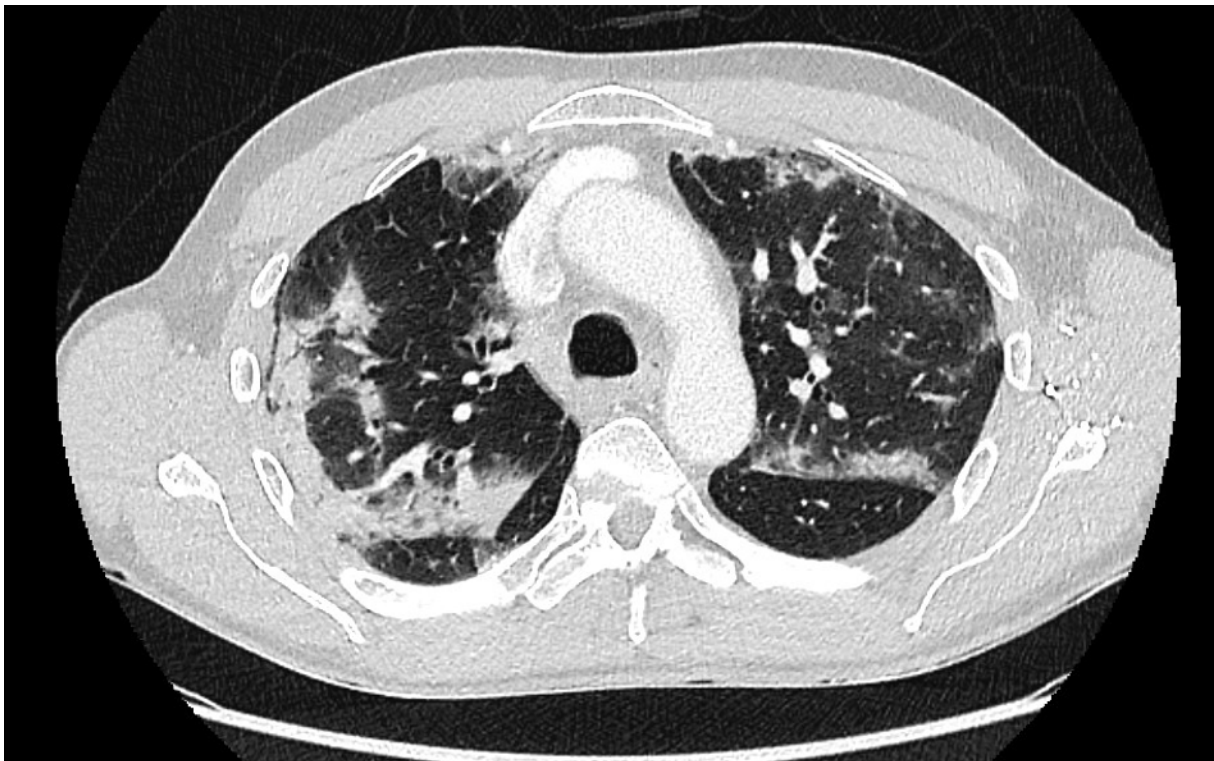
Ground glass opacifications in lung of Covid-19 patient. Picture obtained from computer tomography (CT) scan of lung tissue in a patient with Covid-19, showing ground glass opacifications.
